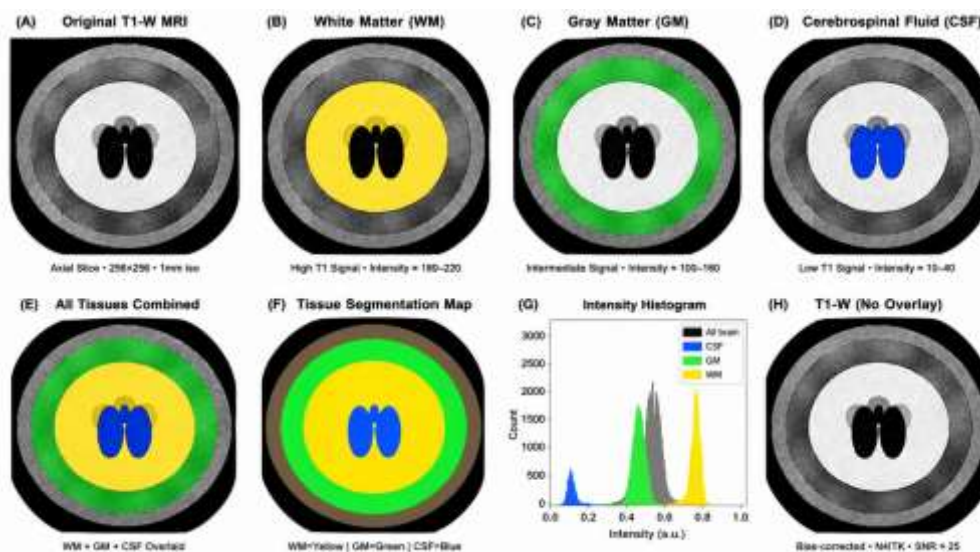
Brain Tissue Classes: 8 Separated MRI Image Panels
